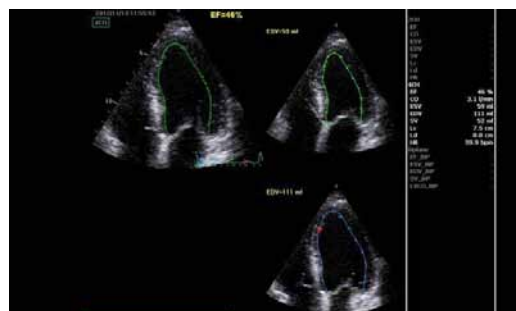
Echocardiogram (apical 4-chamber view) after discontinuing etanercept showing non-dilated LV recovery in LV function.
